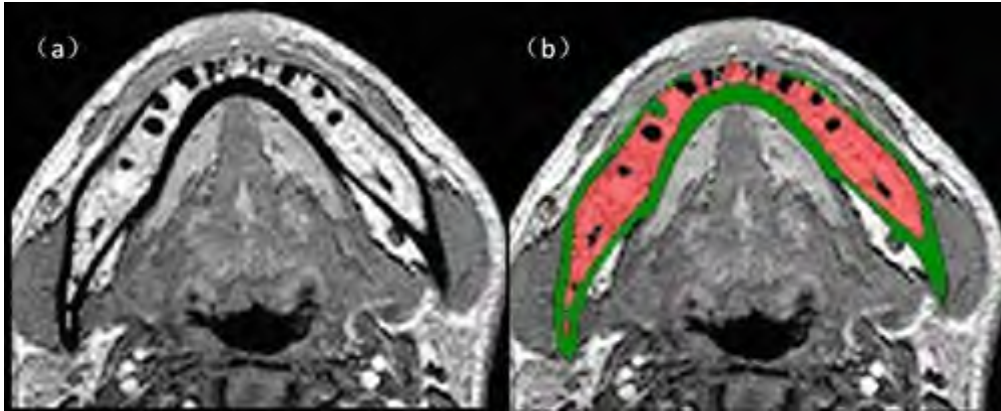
TB and CB are on a typical MRI slice: (a) raw mri image in axial view; (b) the red region is TB and the green region is CB.
